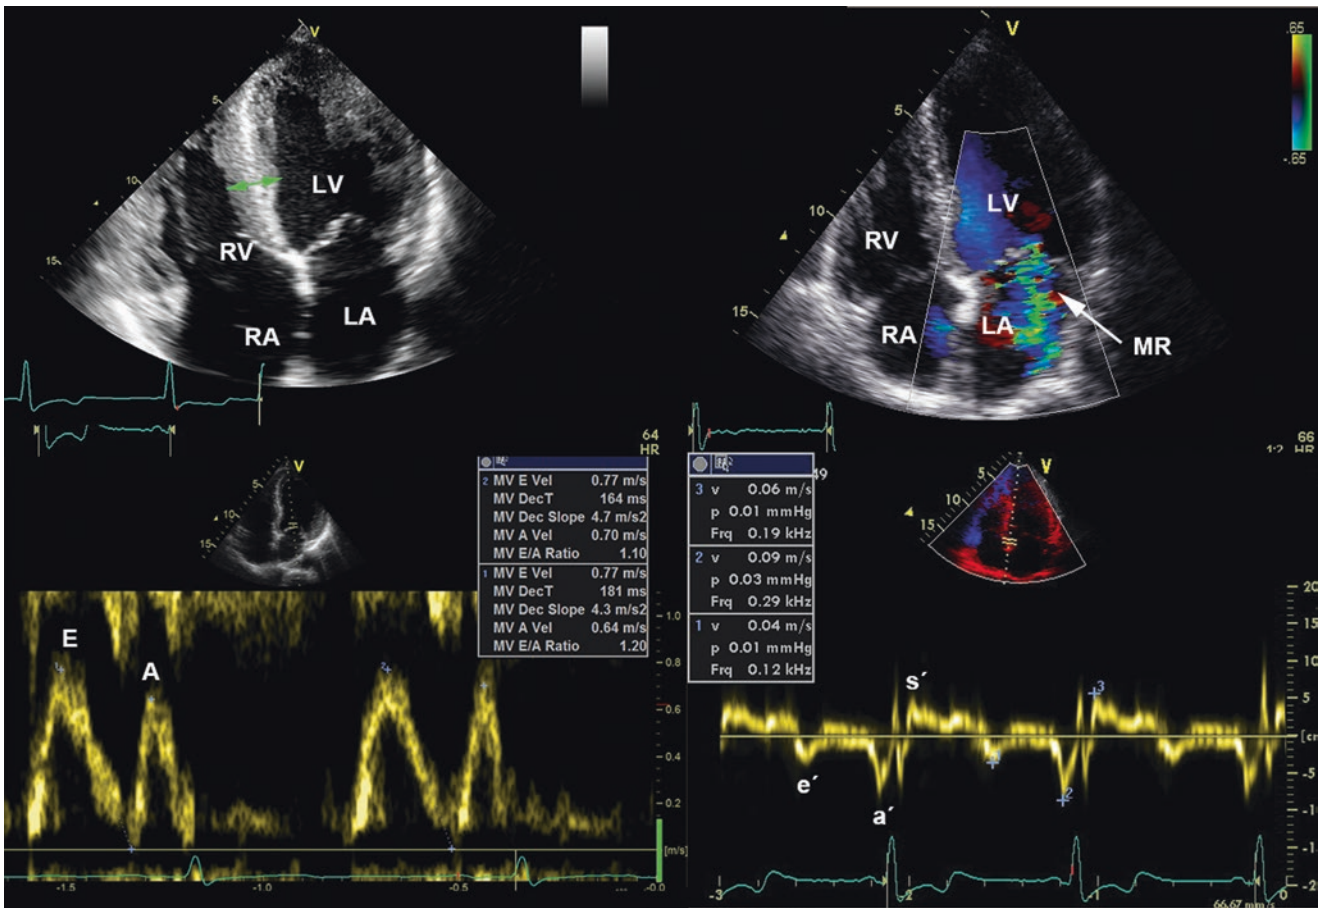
Echocardiographic findings in AFD demonstrating the presence of left (and to a lesser extent also right) ventricular hypertrophy, mild-to-moderate mitral regurgitation due to valvular changes and impaired (pseudonormal) left ventricular filling pattern
